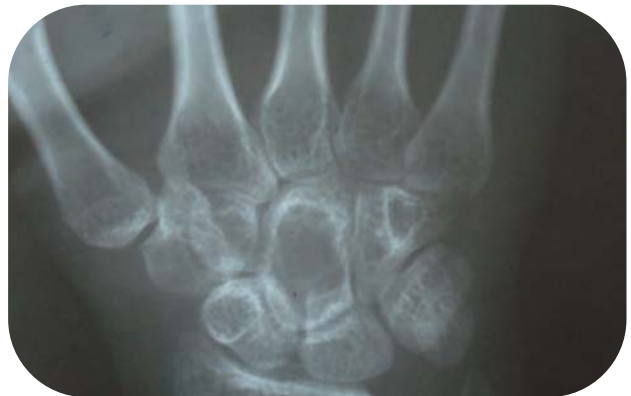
Plain radiograph of wrist showing lytic lesion in Capitate
